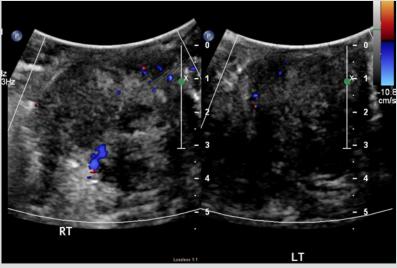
Ultrasound of the testicles showing bilateral heterogeneous enlargement
